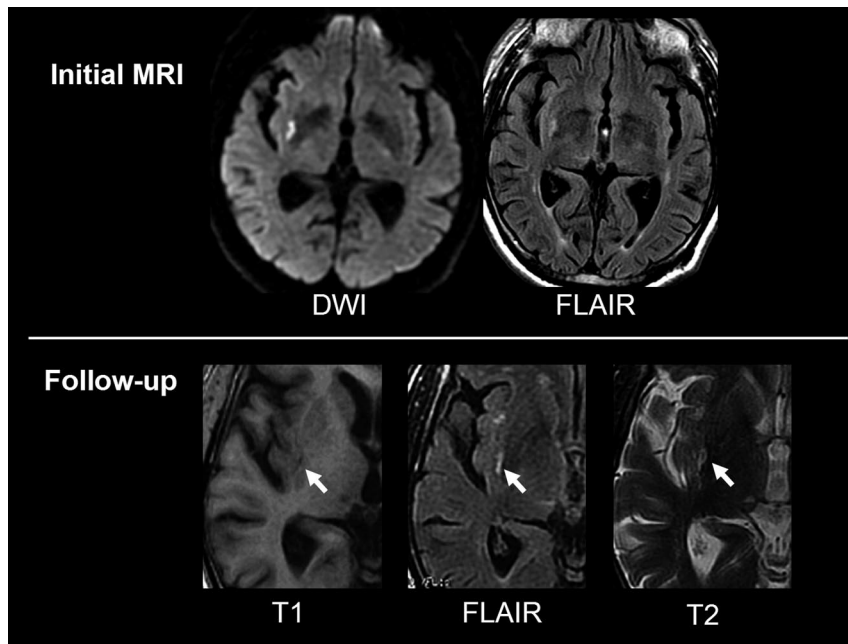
A 67-year-old man with a left sensory-motor deficit for 30 minutes. Initial MR imaging (3 days after onset) demonstrates a small DWI and FLAIR hyperintensity in the deep right middle cerebral artery (MCA) territory. On follow-up MR imaging (14 months after onset), focal signal intensity changes on all sequences indicate permanent injury in the corresponding area.
